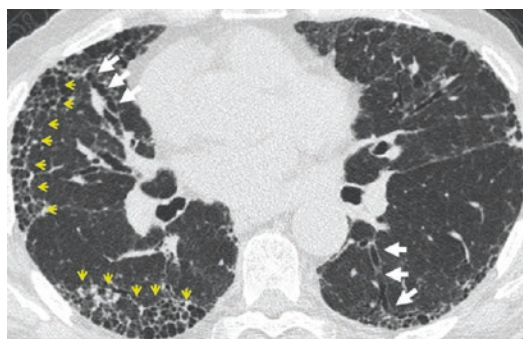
Usual interstitial pneumonia in a 46-year-old female patient with diffuse systemic sclerosis. Chest computed tomography (CT) scan in usual interstitial pneumonia shows a pattern characterized by reticular septal thickening and honeycombing (yellow arrows) with or without traction bronchiectasis (white arrows) with a predominantly subpleural-basal distribution (Figure courtesy of Christos Kampolis, MD)
